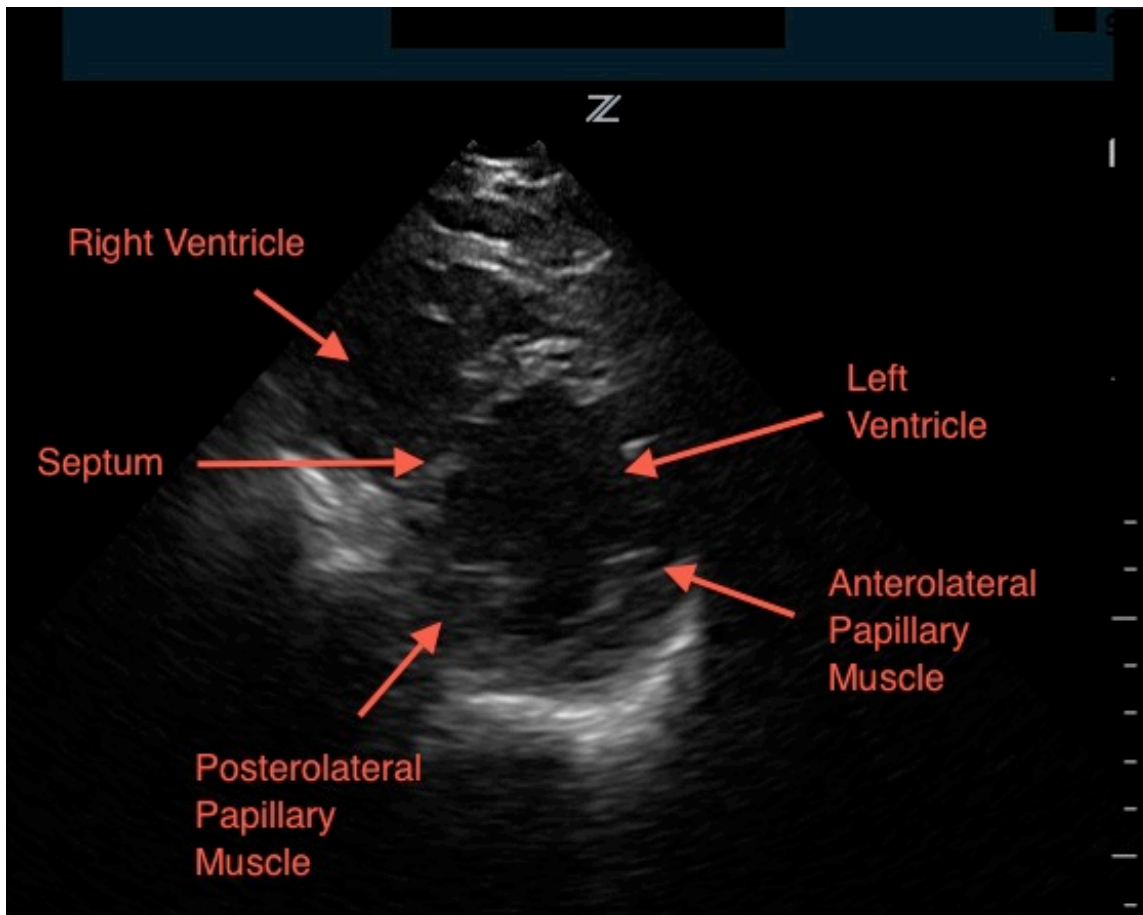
Cardiac Parasternal Short Axis
